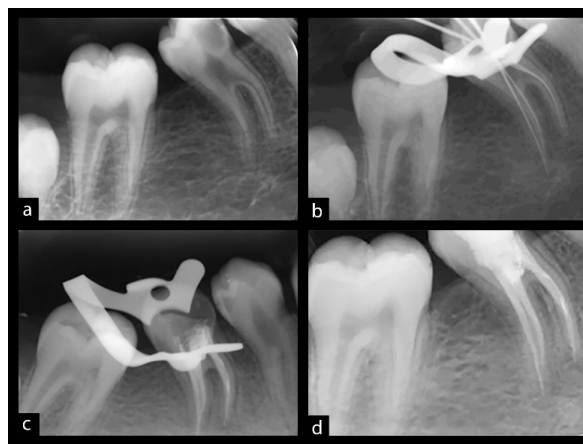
A: Pre-operative radiograph of right mandibular second premolar. B: Working length-determination radiograph demonstrating three root canals. C: Post-operative radiograph. Note three obturated root canals. D: Follow-up radiograph taken after one year.
